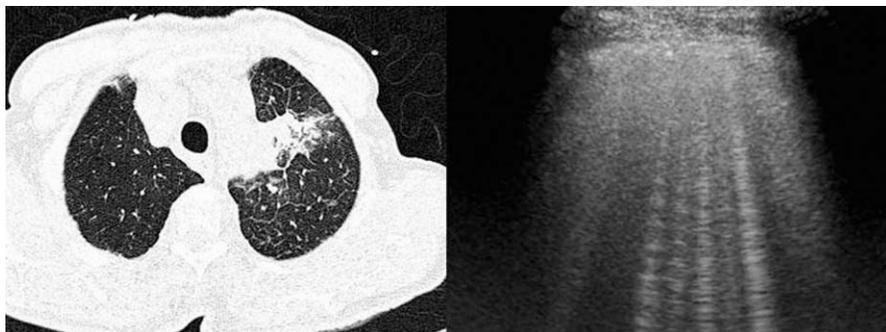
Chest computed tomography scan (left): lung cancer in the upper left lobe with thickening of the interlobular septa indicative of lymphangitic carcinomatosis. Chest ultrasound (right): multiple comet-tail artifacts corresponding to the thickening of the interlobular septa.
